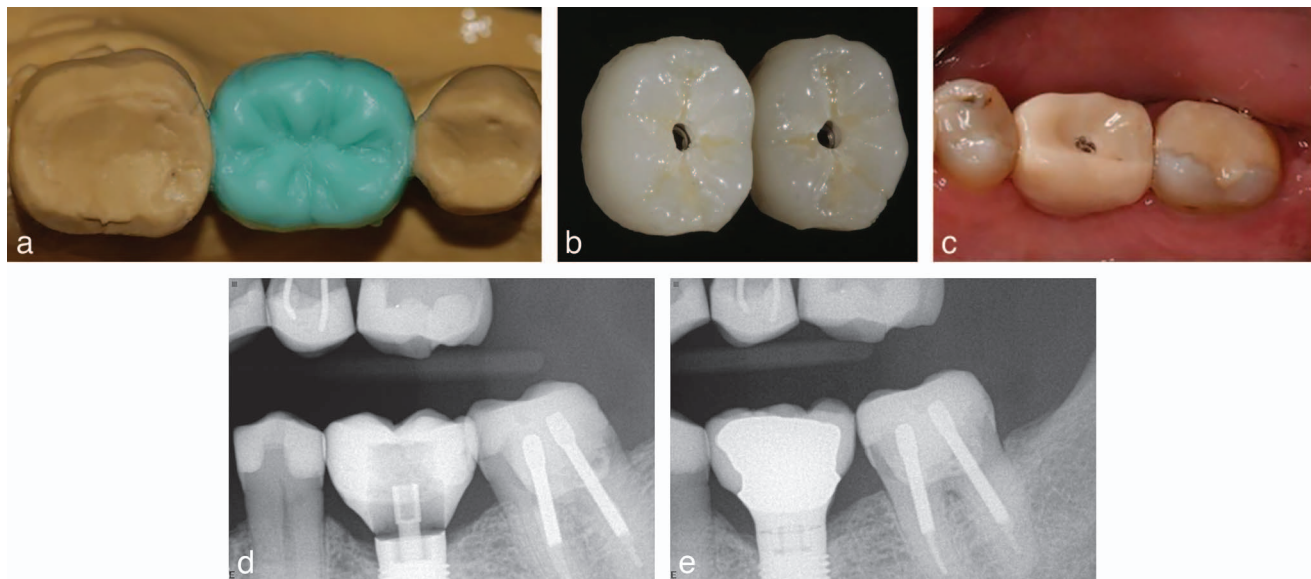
(a) Wax up for provisional crown. (b) Provisional crown. (c) Placement of provisional crown on day of surgery. (d) Radiograph of provisional crown day of surgery. (e) Radiograph of final crown 12 months postsurgery.
